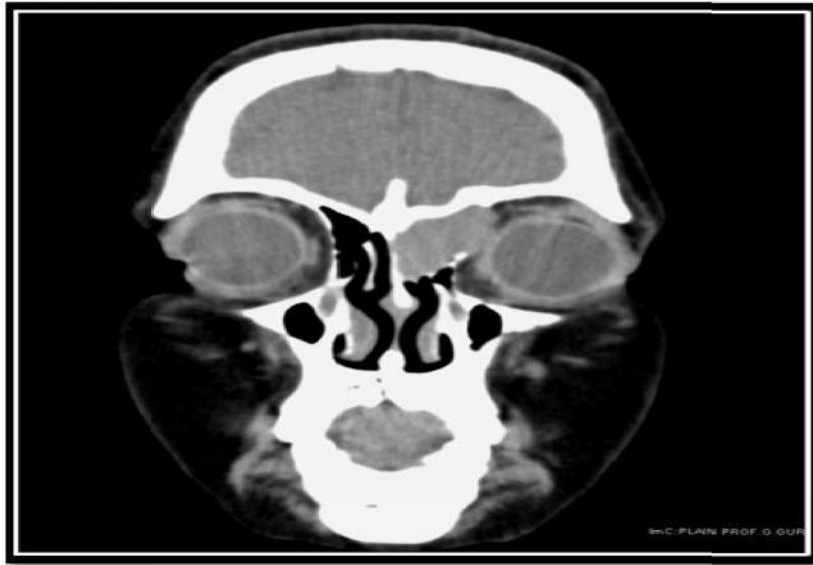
coronal CT showing mucocele; Lt. frontal and ethmoid sinuses opacity and expanded(Timmanagouda, 2008).
